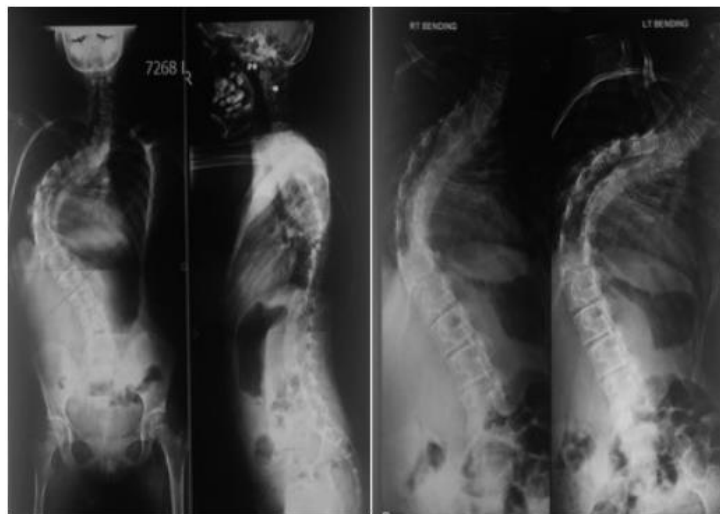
X-ray of whole spine in AP, lateral and side-bending position showed rigid right thoracic scoliosis T3-L1 (Cobb angle 87°) and fixed pelvic obliquity of 10°.
